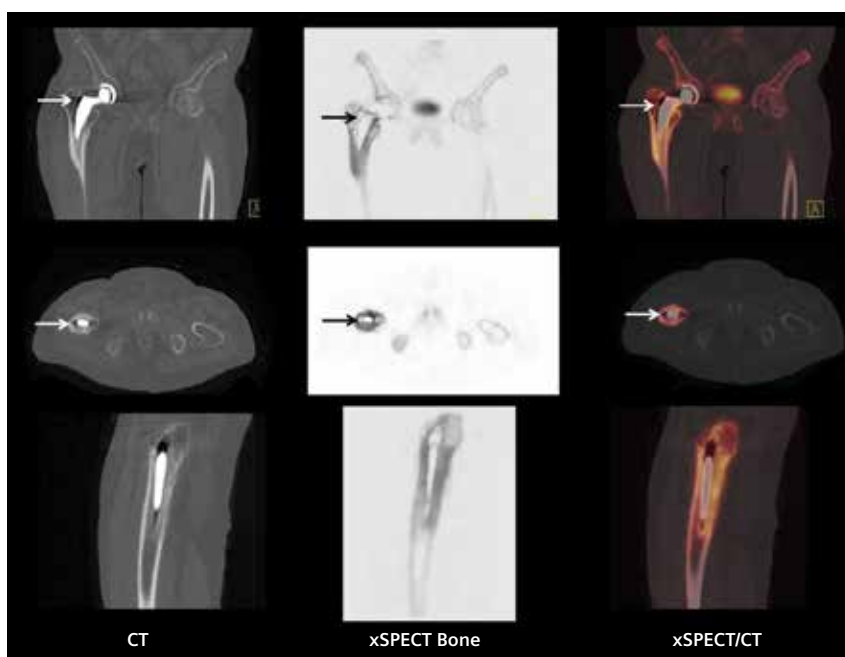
CT shows peri-prosthetic radiolucent zones, enlarged Gruen zones (arrows). Fused xSPECT and CT images show increased uptake in the cortical bone adjacent to the stem of the femoral component of the prosthesis. The uptake pattern suggests loosening of the femoral component.
